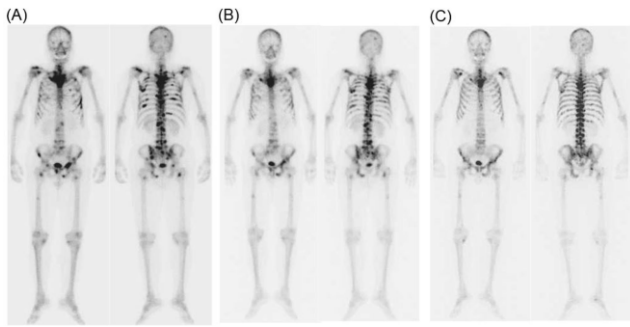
The Tc-99m HMDP bone scintigraphy of a 78 years old man with bone metastases from prostate cancer (A). $^{89}\text{SrCl}_2$ (110MBq) was administered twice every three months, and Zoledronic acid (ZA) at 3mg/body was administered every 4 weeks. The bone scintigraphy three months (B) and six months (C) after treatment shows an improvement of multiple bone metastases. The Numeric Rating Scale (NRS) score decreased from 7 before the treatment to 0 six months after the treatment. The tumoricidal effect was assessed to be partial response (PR).
